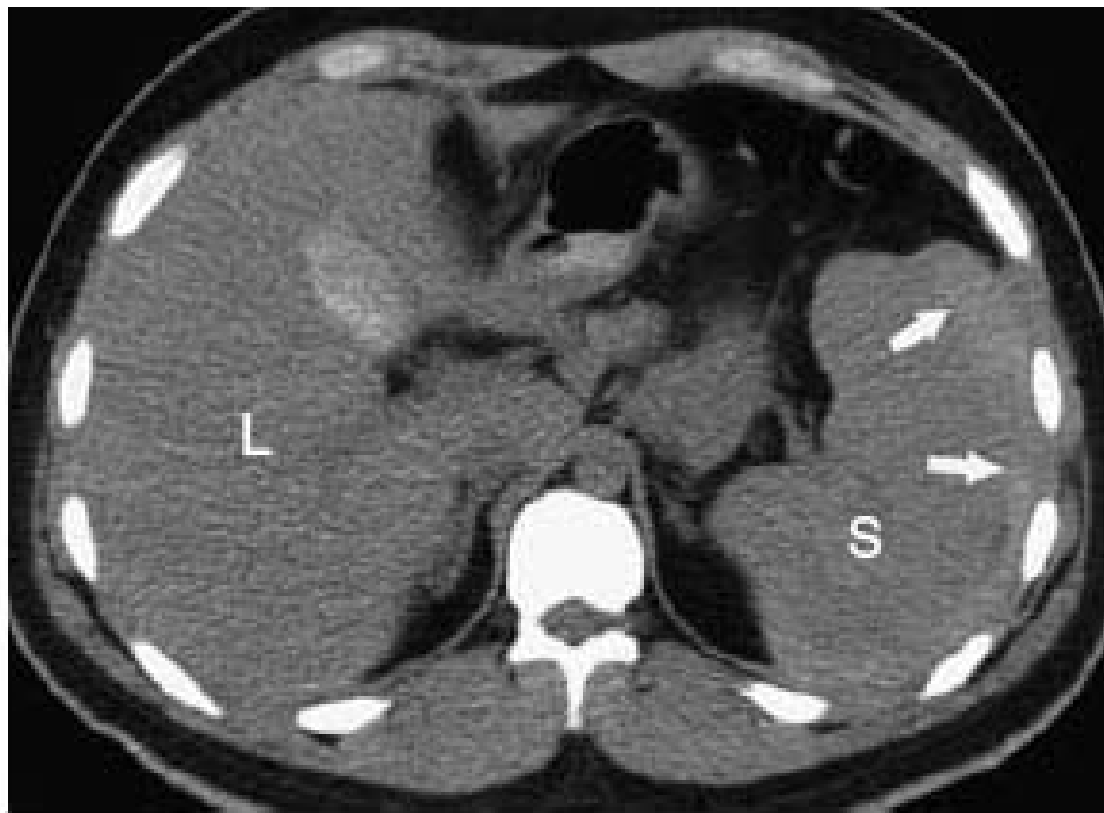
Non-enhanced axial CT scan showed relatively high-density fluid accumulation (arrows) in the left subphrenic space. It is consistent with spontaneous hemoperitoneum. (L, liver; S, spleen).
